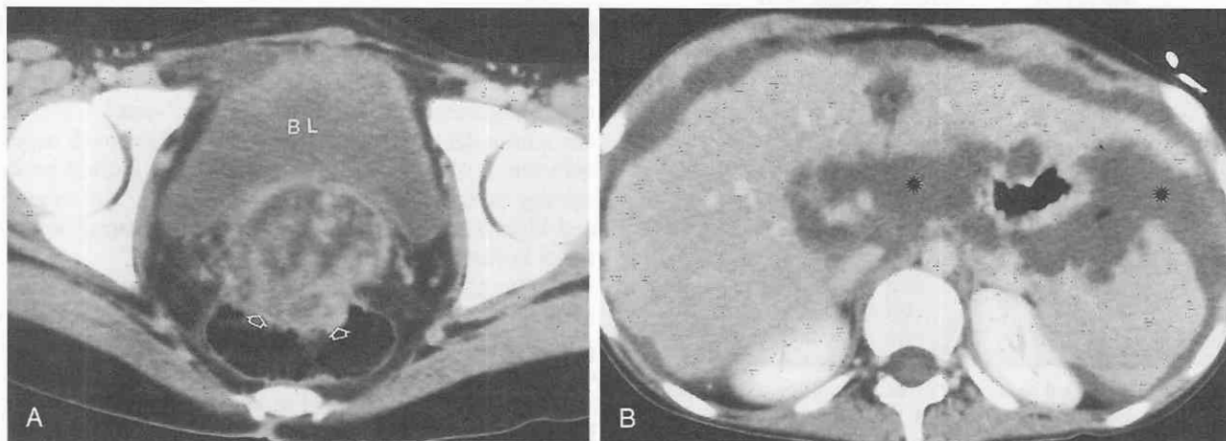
Mucinous ovarian carcinoma. *A*, Contrast-enhanced CT scan of a 14-year-old girl with abdominal distention and weight loss shows a complex cystic and solid mass behind the bladder (*BL*). The tumor has invaded the rectum (*open arrows*) and extended into the parametrial fat. *B*, At a more superior level, there is a soft tissue omental mass (“omental cake”) anterior to the liver and the mesenteric implants (*asterisks*).
